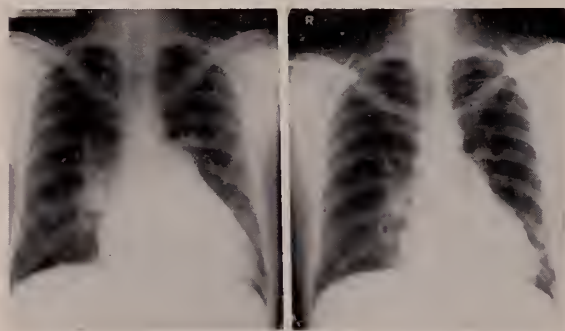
Comparative preoperative and postoperative roentgenograms of a 47 year old patient who had been in frank cardiac failure before closure of the atrial defect. The roentgenogram on the right was taken four months following operation.
